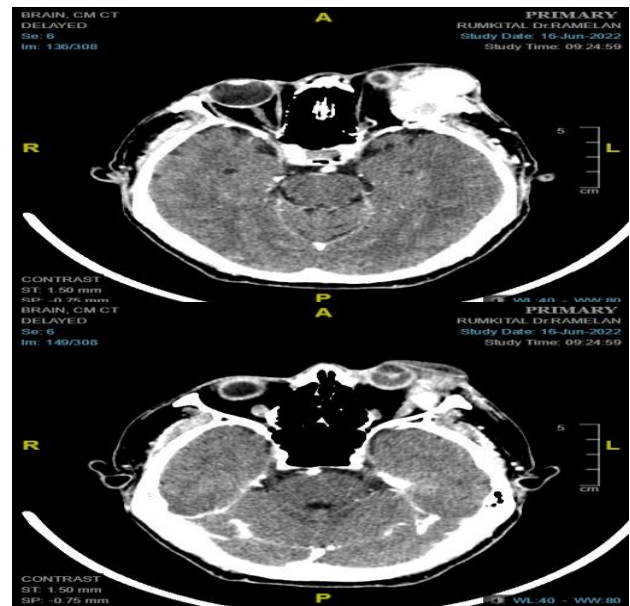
Computed tomography images of the orbit revealed enhanced and infiltrative mass at the left superotemporal orbit.
